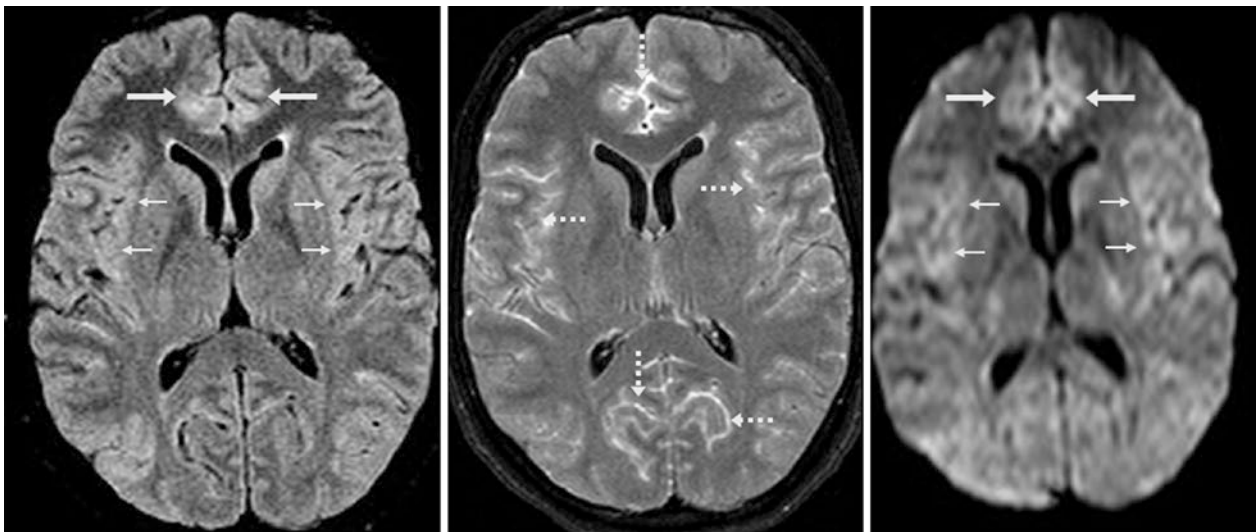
Comparison case of herpes simplex viral (HSV) encephalitis: This 37-year-old underwent a 3 T MRI, which demonstrated subtle, multifocal cortical edema on FLAIR (*left*) and DWI (*right*), particularly
